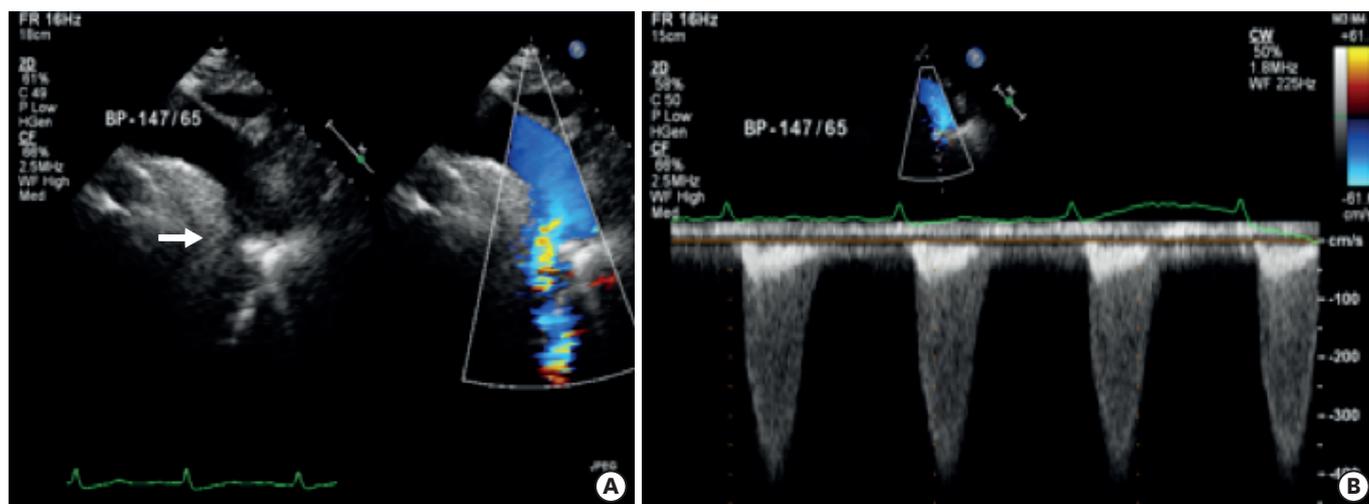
(A) A two-dimensional TTE from the suprasternal view demonstrating a discrete narrowing just distal to the take-off of the left subclavian artery (arrow) with continuous high velocity color Doppler signal across the coarctation. (B) Continuous wave Doppler TTE showing continuation of anterograde flow during diastole and peak pressure gradient of 60 mmHg across the coarctation. TTE = transthoracic echocardiography.
